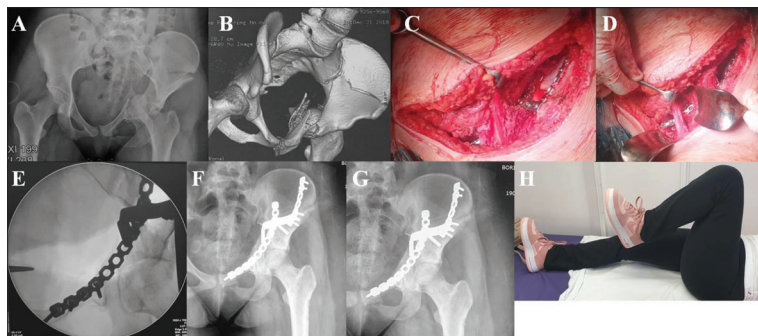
T-fracture of the acetabulum associated with iliac bone fracture in a 20-year-old patient; A: X-ray after the injury; B: 3D computed tomography view; C, D: intraoperative views after fracture fixation through the anterior ilio-inguinal surgical approach; E: intraoperative fluoroscopy; F: postoperative X-ray; G: X-ray six months after the injury; H: functional outcome, after six months post-injury was excellent
